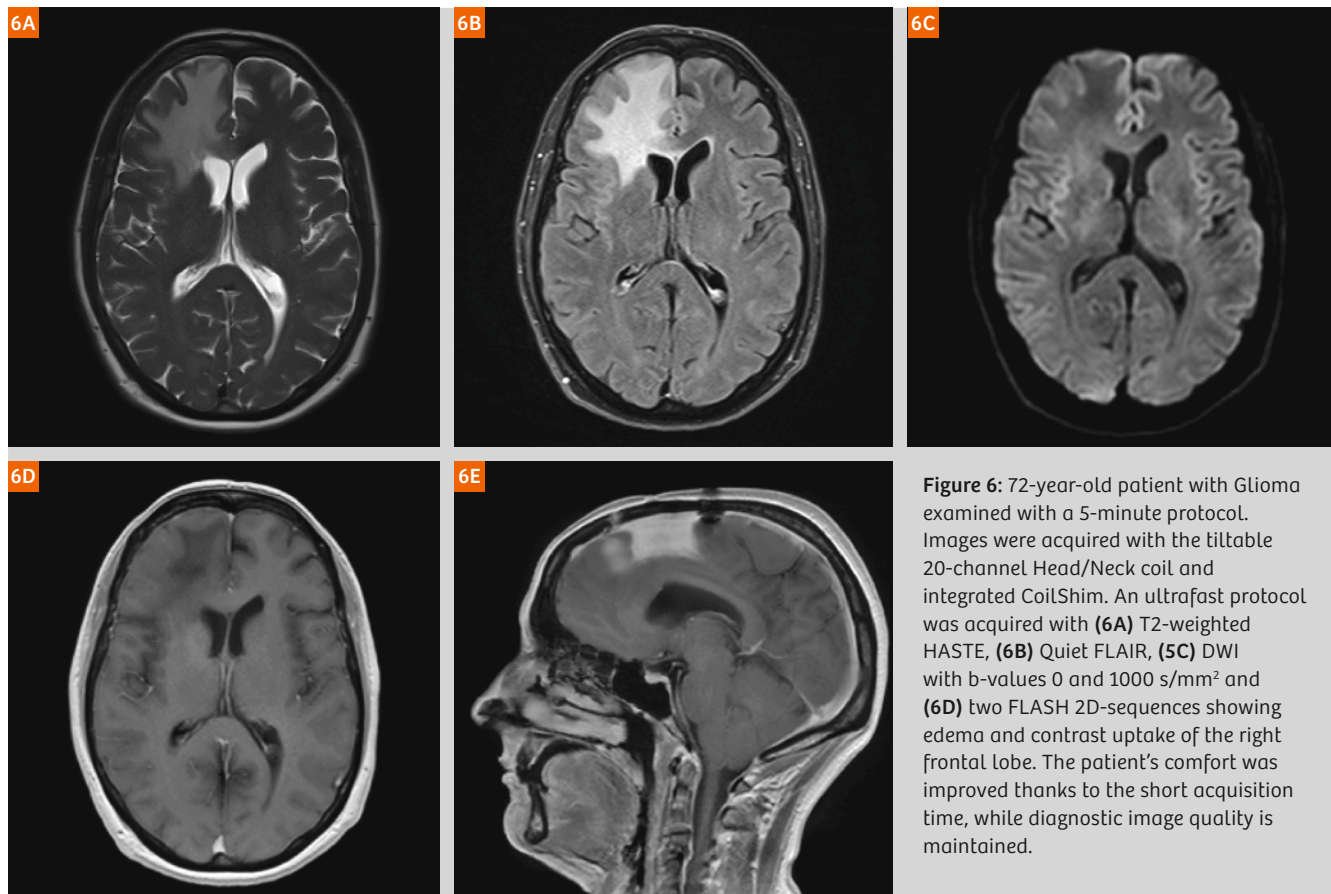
72-year-old patient with Glioma examined with a 5-minute protocol. Images were acquired with the tiltable 20-channel Head/Neck coil and integrated CoilShim. An ultrafast protocol was acquired with (6A) T2-weighted HASTE, (6B) Quiet FLAIR, (6C) DWI with b-values 0 and 1000 s/mm² and (6D) two FLASH 2D-sequences showing edema and contrast uptake of the right frontal lobe. The patient's comfort was improved thanks to the short acquisition time, while diagnostic image quality is maintained.
